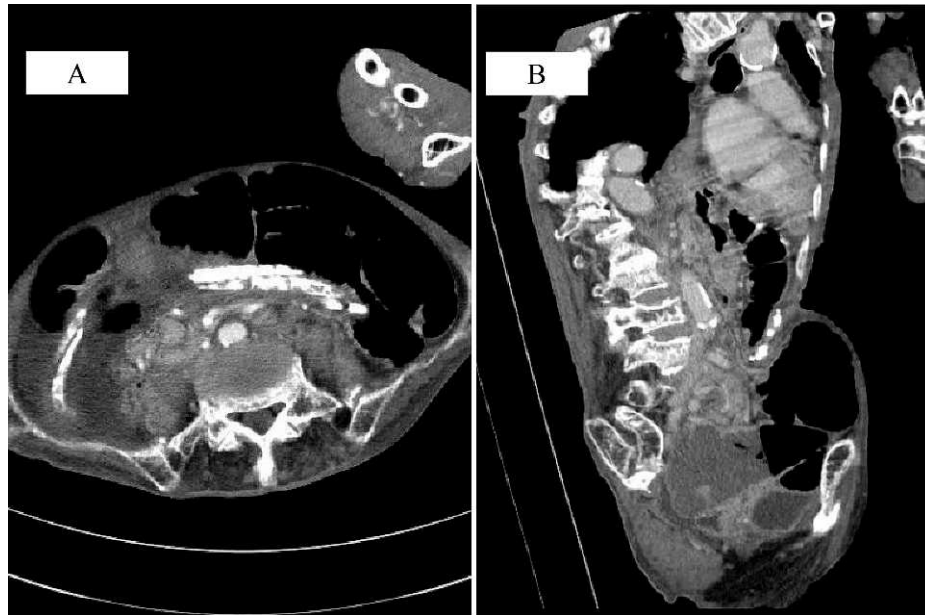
An abdominal contrast CT image. (A) Horizontal section. (B) Sagittal section.
